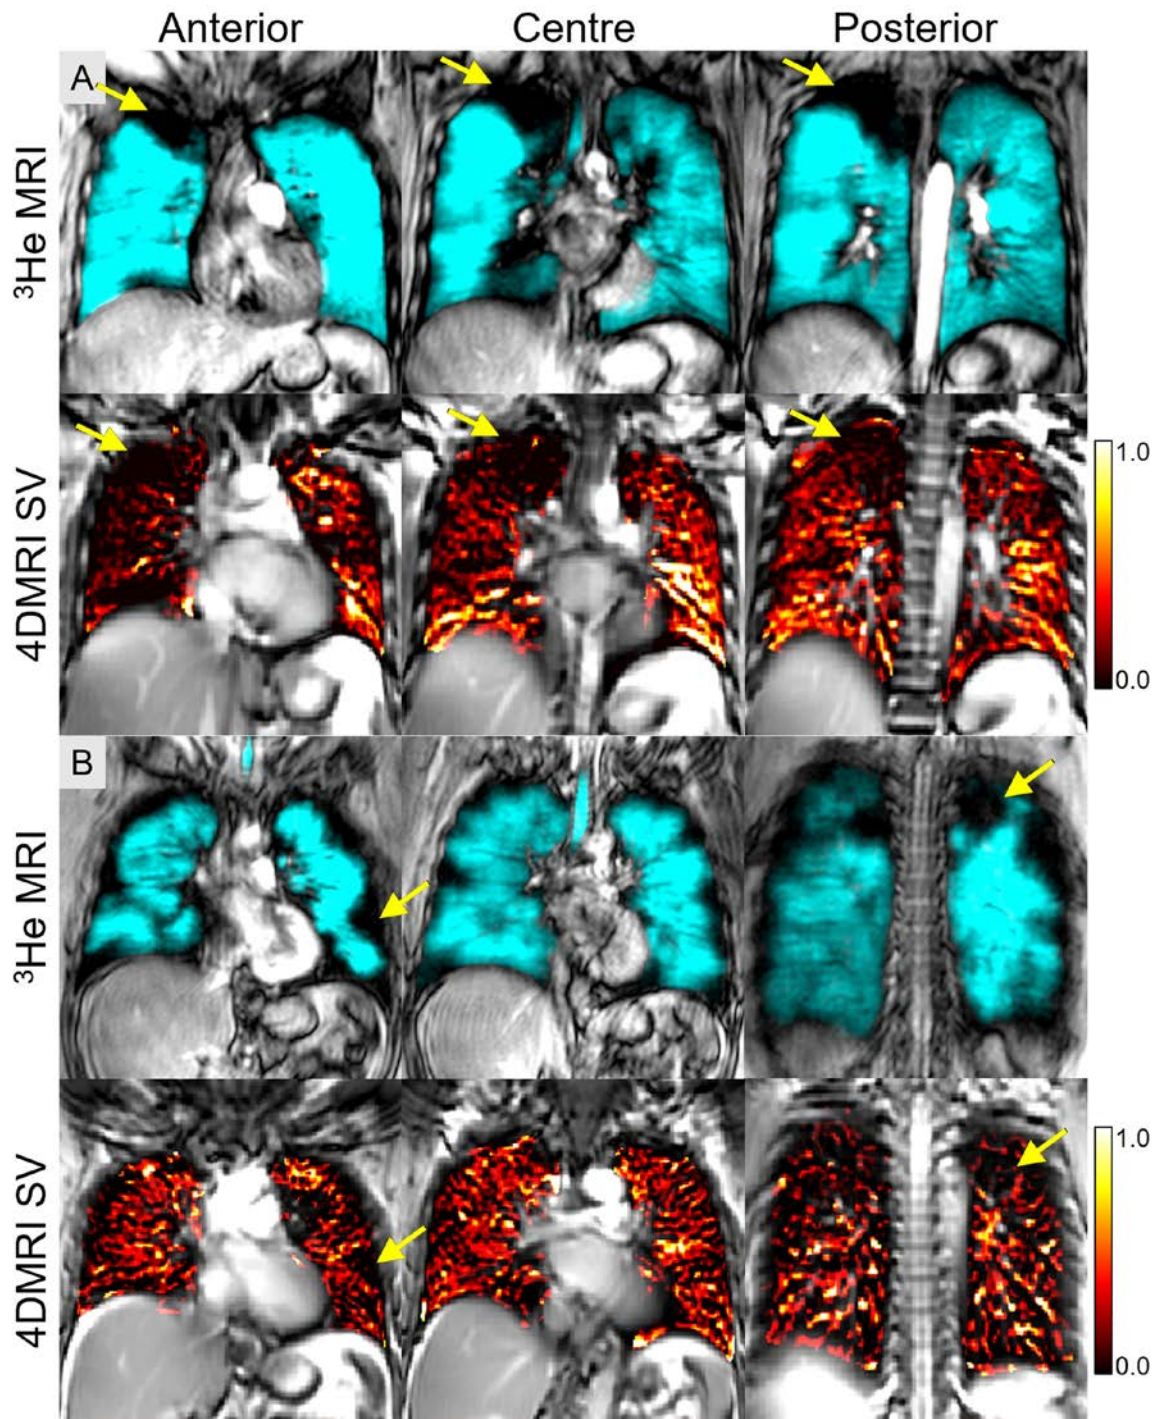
^3He MRI and 4DMRI for Representative Asthmatics
